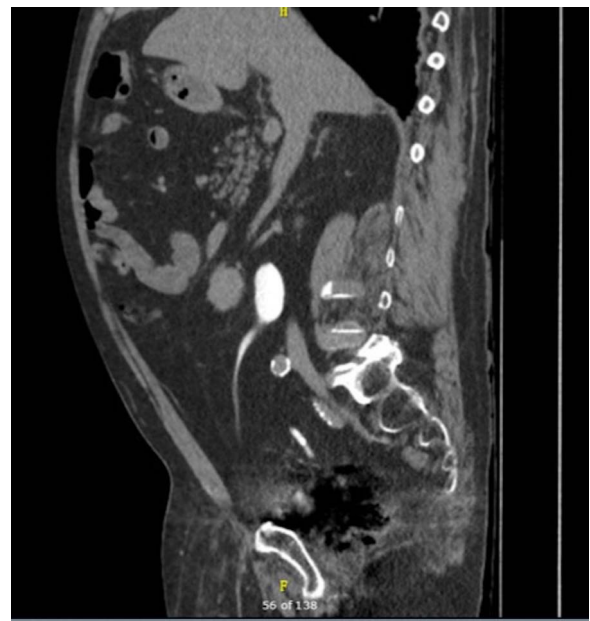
Sagittal view of CT intravenous pyelogram showing dilated proximal right ureter extending down to inguinal canal (arrow). Note that retroperitoneal structures, including the pancreas (A), are sitting forward and extending down into hernia sac (B).
